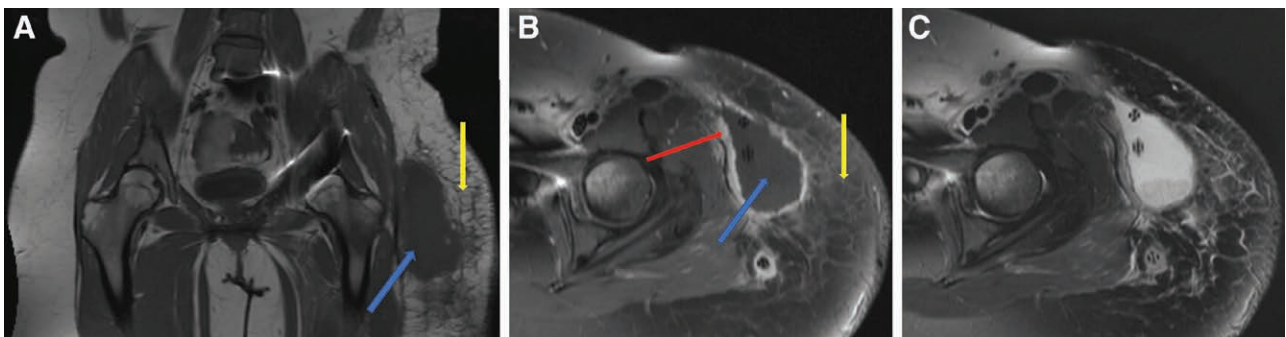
MRI with and without contrast of left hip Morel-Lavallée lesion persisting 6 months after motor vehicle collisions with associated pelvic fracture. A, Coronal T1-weighted image of left hip Morel-Lavallée lesion (blue arrow) with surrounding subcutaneous edema (yellow arrow). B, Contrast-enhanced axial T1-weighted fat-suppressed image showing chronic lesion with thick, irregular, enhancing rim (red arrow) surrounding fluid collection (blue arrow). Two drainage catheters are seen traversing the fluid collection, and a third is shown inferiorly within a collapsed cavity. Note the surrounding subcutaneous edema and stranding suggestive of cellulitis, which this patient did display clinically. C, Axial T2-weighted image of the same lesion.
